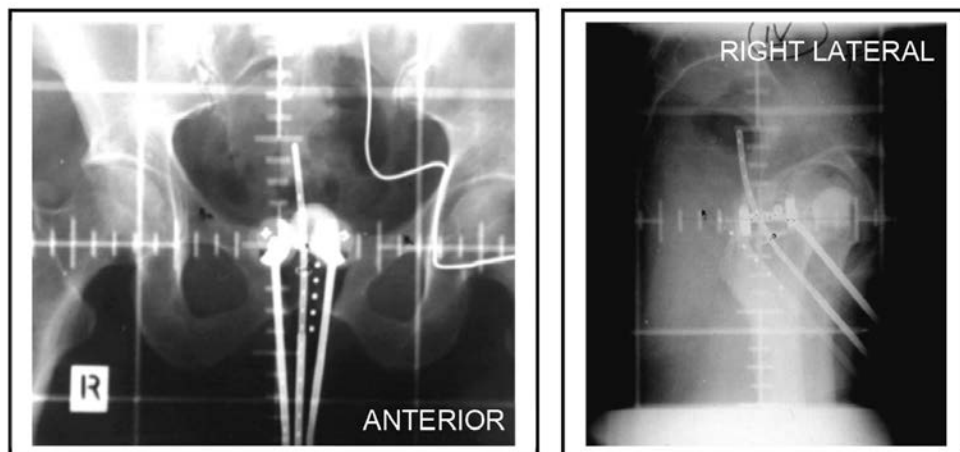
Anterior and lateral radiographs following insertion of applicators for HDR-BT; the white dots indicate the position of a flat rectal retractor.
